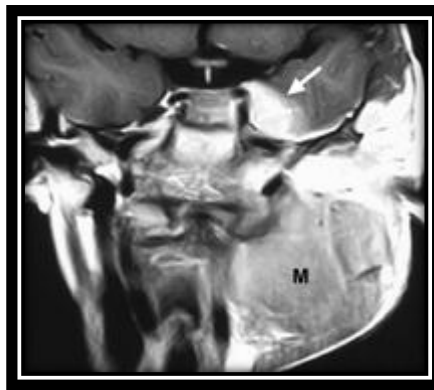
NHL of the neck in a 4-year-old boy. Coronal contrast-enhanced T1-weighted MR image shows a large laterocervical mass (*M*) involving the parapharyngeal space. Infiltration of the left cavernous sinus (arrow) and dural involvement with intracranial extension are evident (*Toma et al., 2007*).
